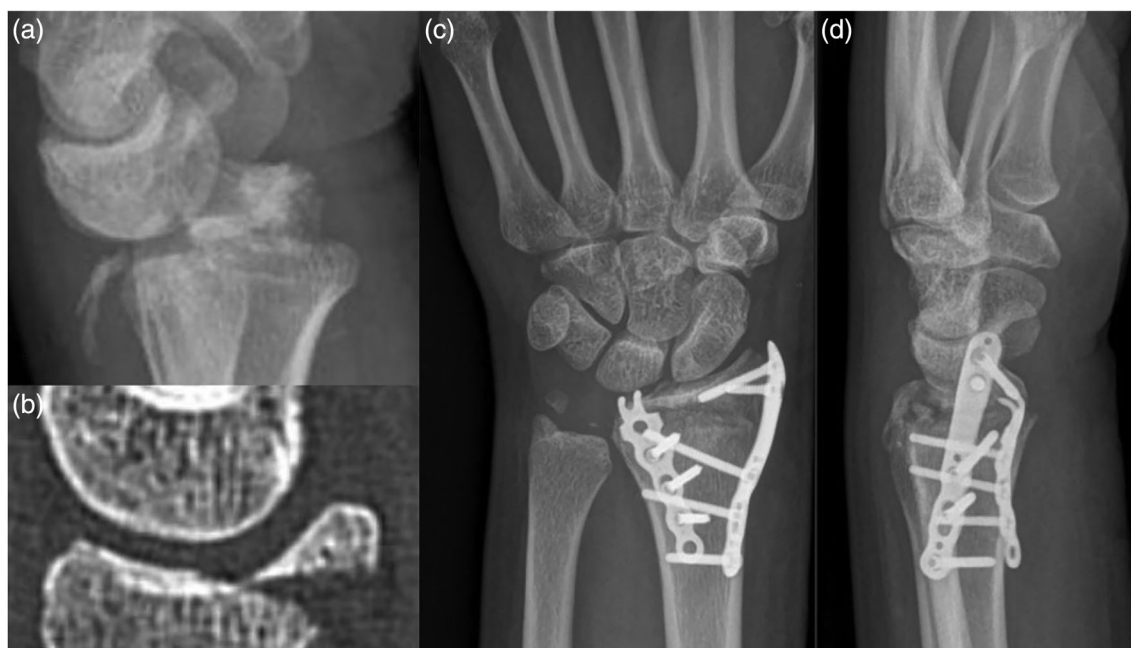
Type I injury (a) lateral radiograph showing the small dorsal and large teardrop volar bony fragment with dislocated lunate. (b) sagittal CT view showing the similar findings in the reduced joint (c) posteroanterior (PA) view after fixation of the teardrop fragment with specific volar ulnar plate and styloid fixation with a plate through a separate radial approach.
